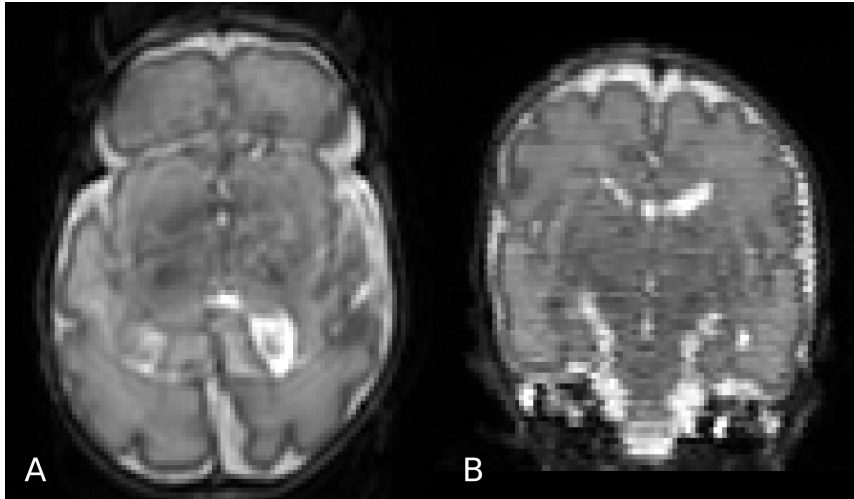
Motion artifacts on a neonatal T2 MR image acquired at 31 weeks PMA. Motion is evident with ghosting effects in the slices of the phase encoding direction (A) and mis-alignment of the slices along the direction (B).
